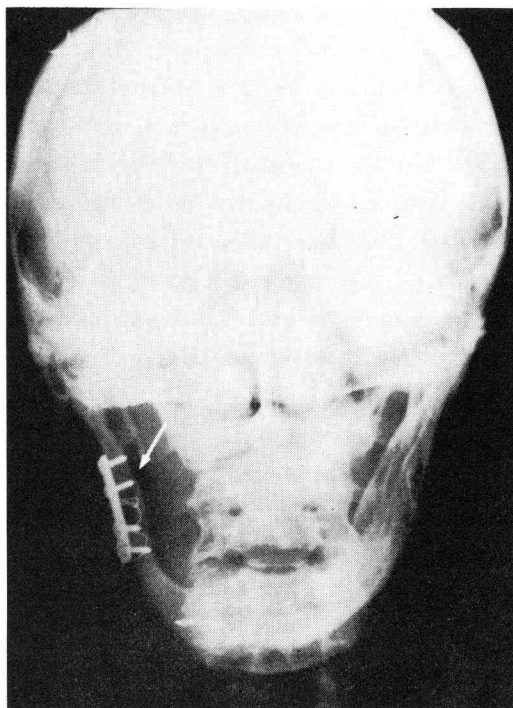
Posterior radiograph the second year after metal plate fixation and the iliac bone regraft (arrow) of Case 5.
